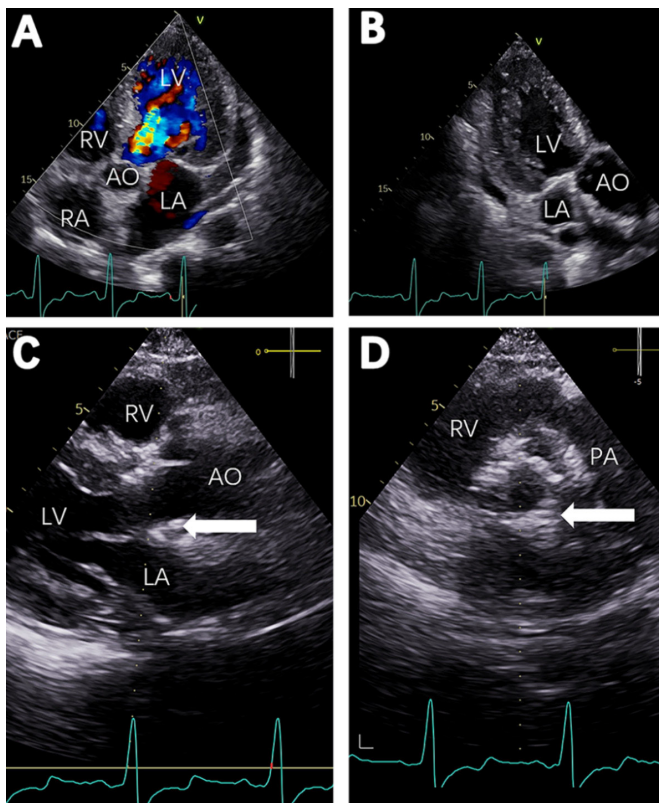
Preoperative echocardiograms (A and B) indicated severe aortic regurgitation. Postoperative echocardiograms at 0.5-year follow-up (C and D) showed the aortic valve prosthesis (arrow). AO, ascending aorta; LA, left atrium; LV, left ventricle; PA, pulmonary artery; RV, right ventricle; RA, right atrium
